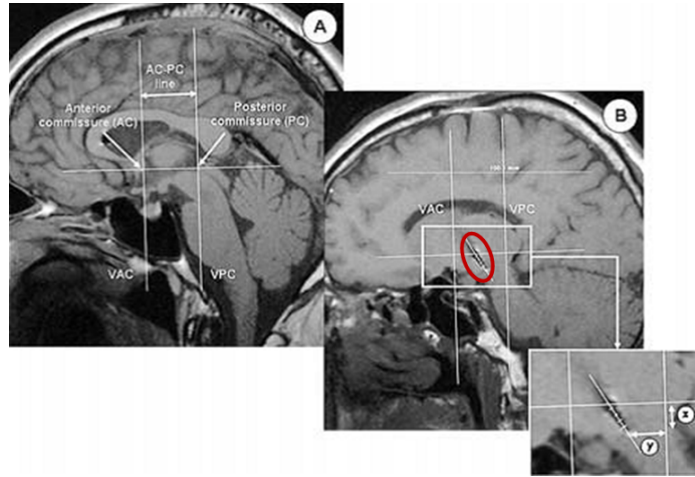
(A): postoperative sagittal SET1 MRI slice for measurement of the AC-PC line, reference axis for z coordinate determination. (B): determination of the anteroposterior y and dorsolateral z coordinates of the electrode's contacts. VAC, vertical line (orthogonal to the AC-PC line) passing through the AC; VPC, vertical line (orthogonal to the AC-PC line) passing through the PC, reference axis for y coordinate determination. Adapted from [5].
